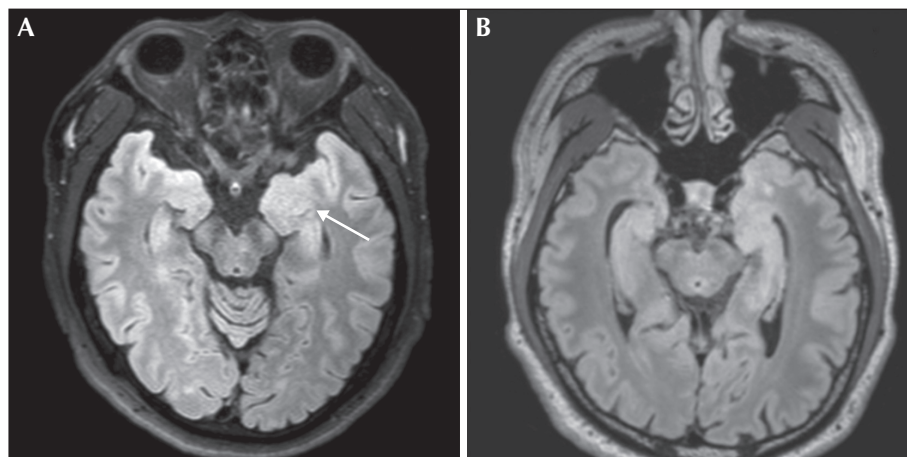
The enlarged amygdala and MRI-negative hippocampus (Case 6). (A) Axial fluid-attenuated inversion recovery (FLAIR) shows the left enlarged amygdala with slightly increased intensity (white arrow). (B) Axial FLAIR shows normal bilateral hippocampi.
